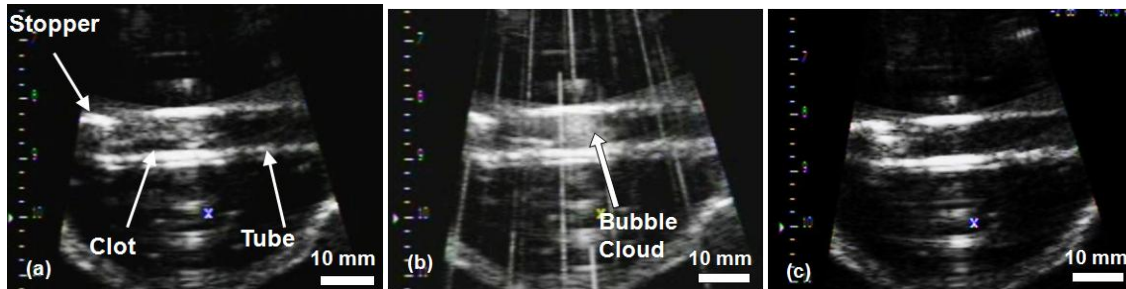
B-Mode images of the histotripsy thrombolysis treatment using a 5 MHz imaging probe. The imaging probe is approximately 8 cm from the ultrasound focus. The ultrasound propagation is from top to bottom of the image. The clot is visible in the tube as an echogenic region prior to insonation (a). The bubble cloud is visible during treatment in (b). The vertical lines in (b) are acoustic interference of the therapy transducer with the imager. However, most of the image remains uncorrupted. The echogenicity of the clot is greatly reduced after complete thrombolysis (c).
